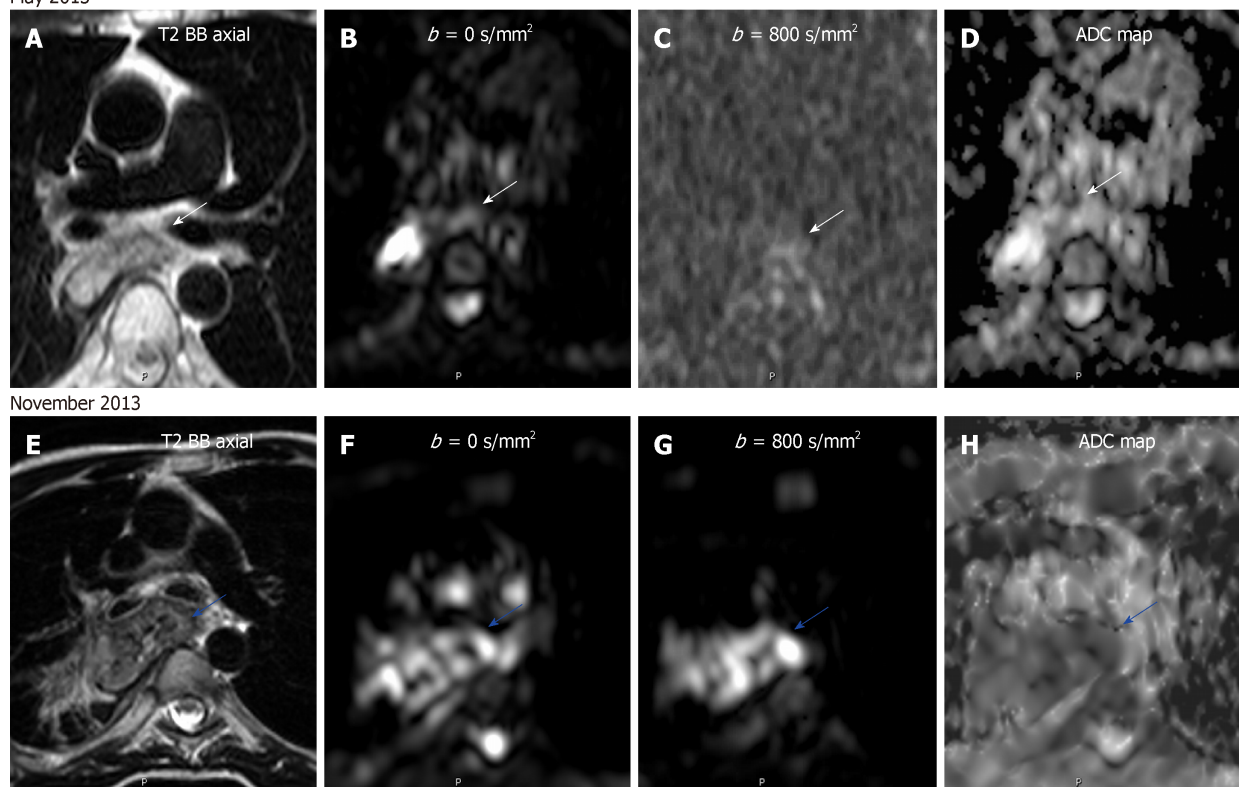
Treatment monitoring of an esophageal carcinoma by diffusion-weighted imaging. A 47 year-old male with esophageal carcinoma treated with esophagectomy and gastroplasty. A-D: Post-surgery surveillance magnetic resonance (MR) shows a normal appearing anastomosis on turbo spin echo (TSE) T2-weighted sequence and with no restriction on diffusion-weighted imaging and apparent diffusion coefficient (ADC) map (B-D; white arrows); D-G: Follow-up MR examination done 6 mo later revealing anastomotic thickening on TSE T2-weighted image and with restrictive behavior on diffusion-weighted whole-body imaging and ADC map (F-H), in keeping with relapse (blue arrows). ADC: Apparent diffusion coefficient.
